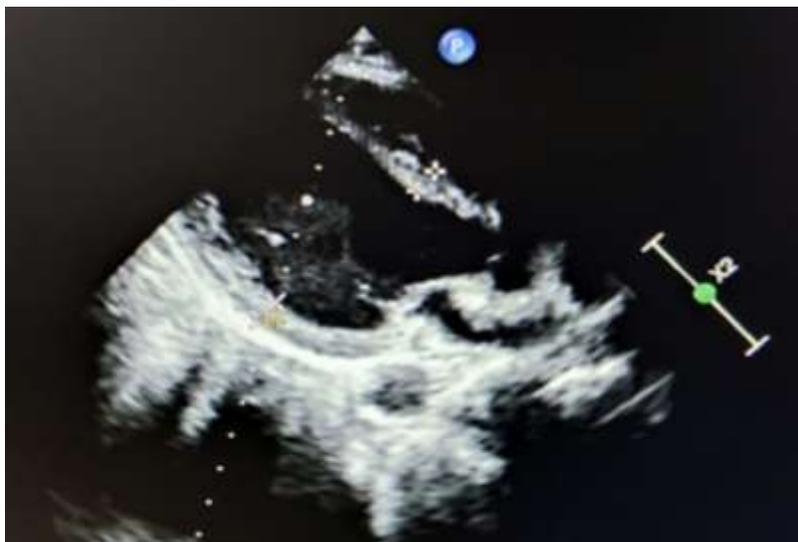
Echocardiography showing normal IVS and posterior wall thickness
